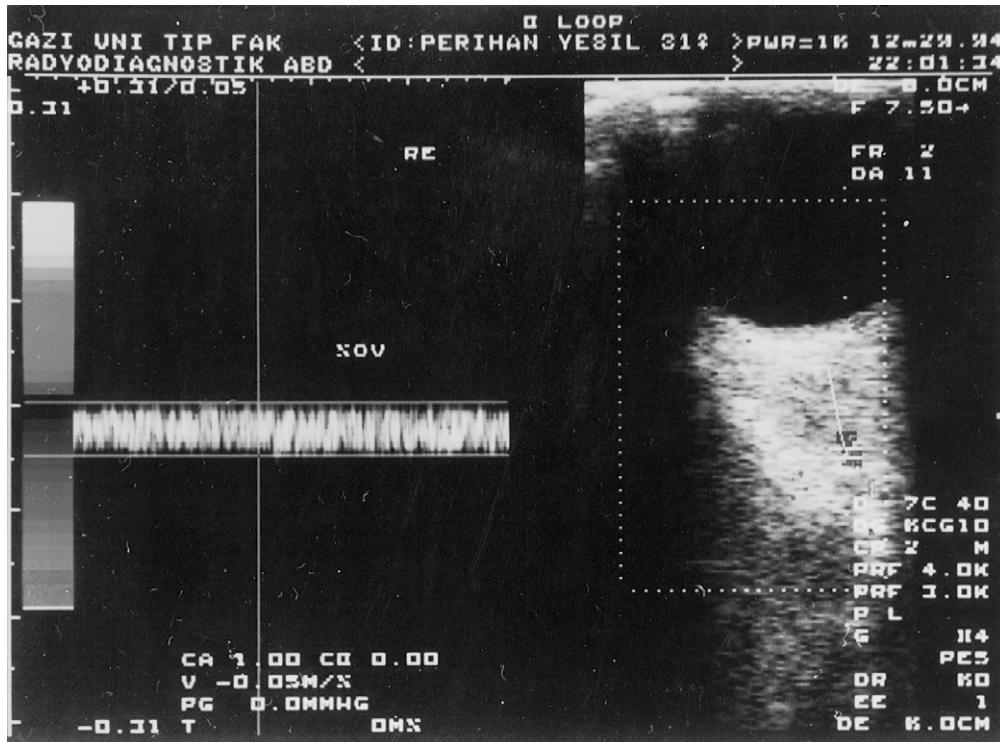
Colour Doppler imaging demonstrating the superior ophthalmic vein in the right orbit of a patient with thyroid associated eye disease. The nonpulsatile venous flow is directed away from the transducer and is therefore coded blue. Spectral analysis (on the left) confirms the characteristic venous flow pattern.
